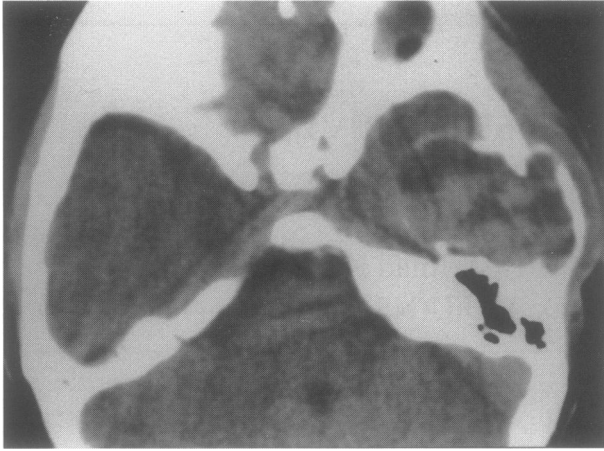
Noncontrasted CT scan of the head showing a temporal fossa lesion. The lesion is of multiple densities. Fluid levels are demonstrated between the lower hyperdense and the upper hypodense fluids.
